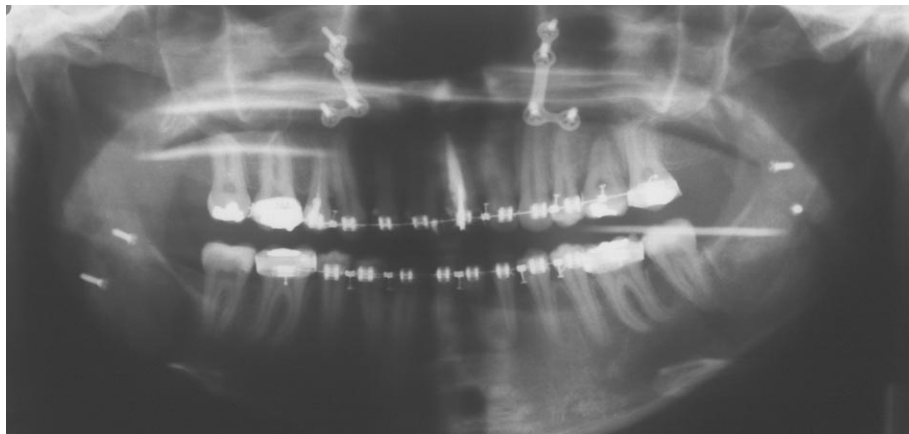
Panoramic radiograph, 10 months after autotransplantation.
